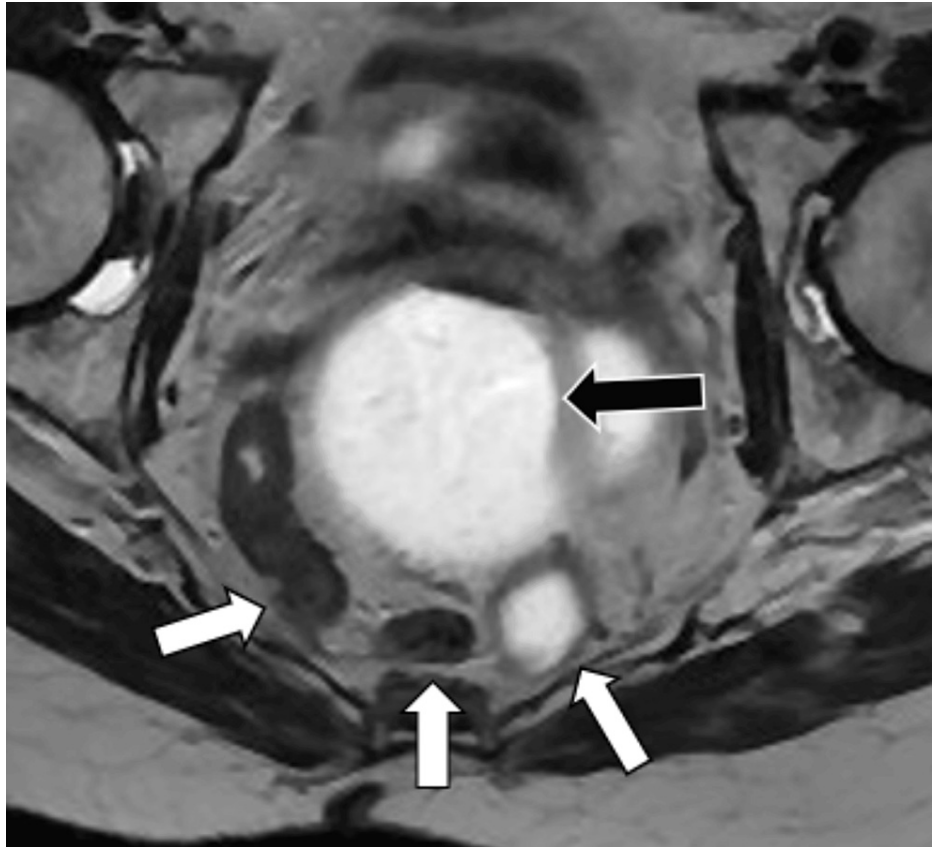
Axial T2-weighted image of the pelvis during MR defecography showing loops of the sigmoid colon (white arrows) in the presacral space – posterior to the distended rectum (black arrow).
